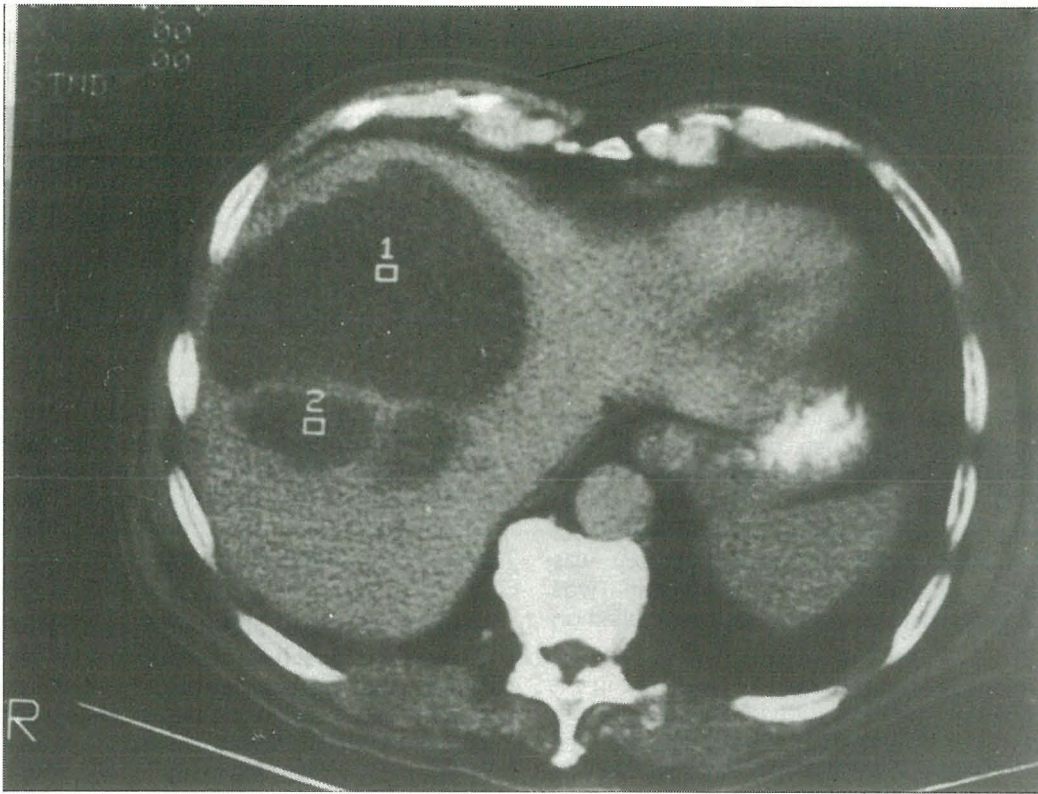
CT Scan at level of T12
